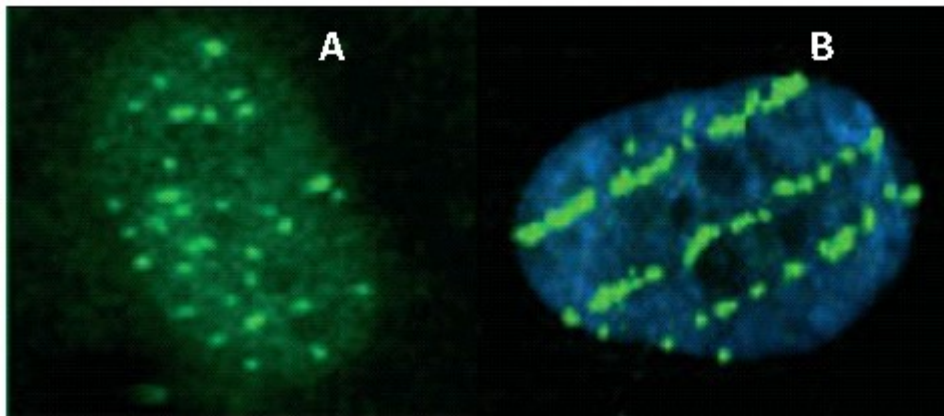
Experimental evidence of differing patterns of ionization events produced by sparsely (X-rays, A) and densely (^{12}C ions, B) ionizing radiation by means of an immunofluorescent technique.
